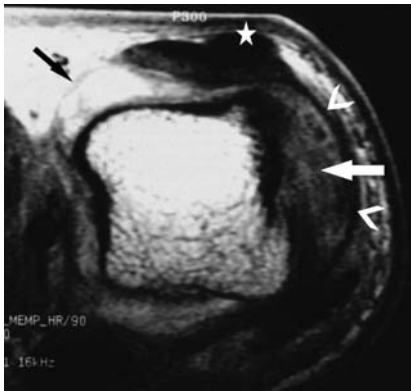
MR image of a complete tear of the radial collateral ligament of the second right MCP joint associated with a tear of the ulnar sagittal band. Axial T1-weighted (600/24) contrast-enhanced image of the flexed MCP joint shows the thickened and enhanced radial collateral ligament (*white arrow*) with the displaced normal radial sagittal band (*arrowheads*). The ulnar sagittal band appears disrupted (*black arrow*) with subluxation of the extensor tendons (*star*) on the radial side
